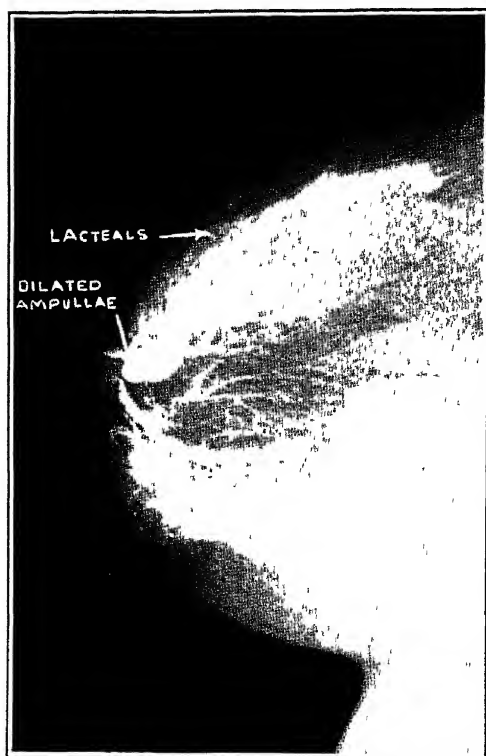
Multiparous breast injected with thorotrast. The small lacteals indicate a poorly functioning gland. No disturbance in the normal distribution of the ducts. (Am J Roentgenol, March, 1938.)
